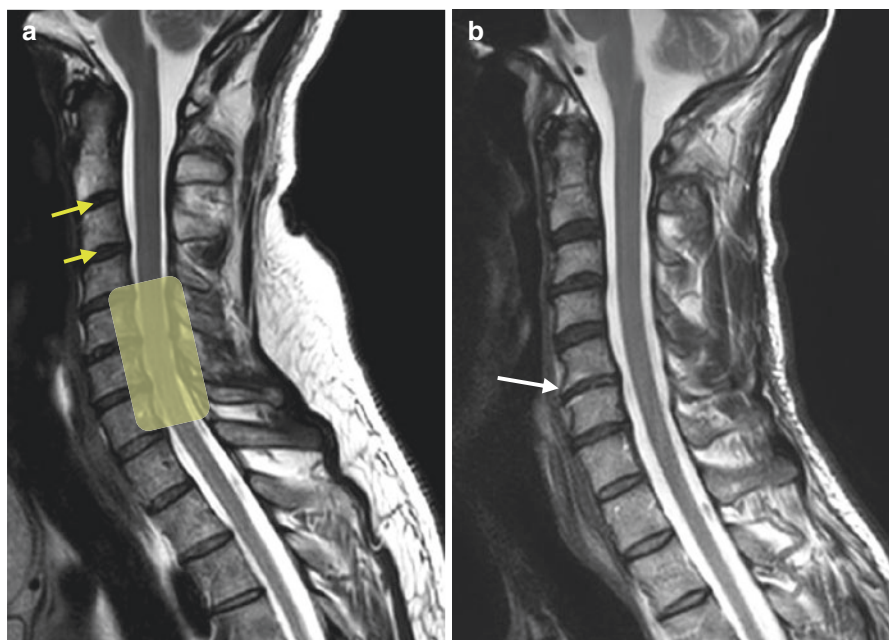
MRI of the cervical spine in osteoarthritis
